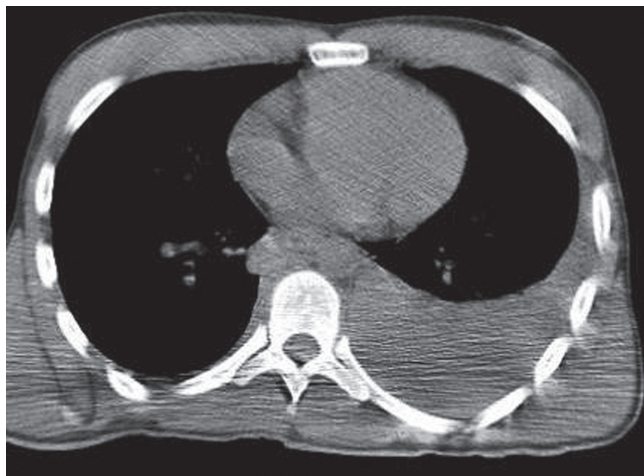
Hemothorax is seen on thoracic computed tomography (CT).
